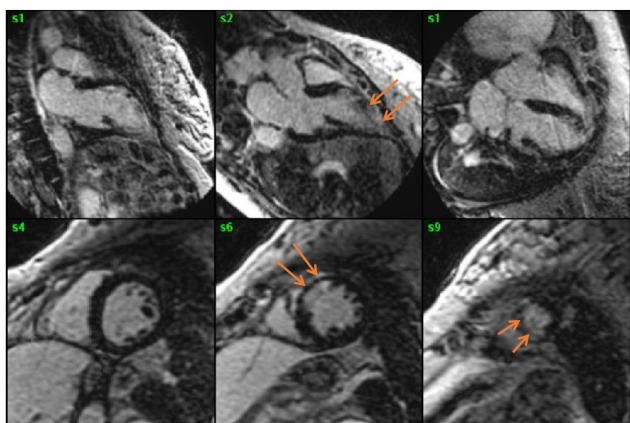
Cardiac MRI revealing late gadolinium enhancement of the mid to distal anteroseptal wall (arrows). Still frames from horizontal long axis (top row) and short axis (bottom row) are consistent with mid to distal LAD infarction
